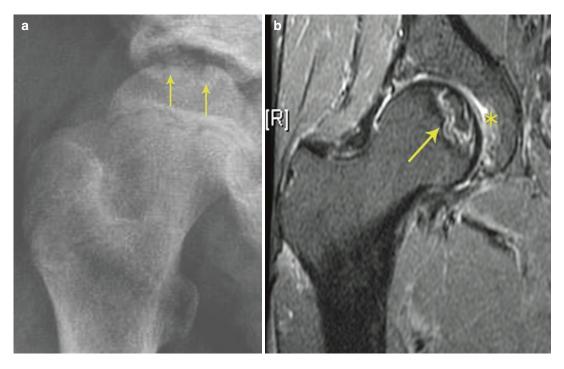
Avascular necrosis (AVN) in a 56-year-old man treated for 30 years with 15 mg prednisone for RA. (a) Plain radiograph with collapsed femoral head (*arrows*)
